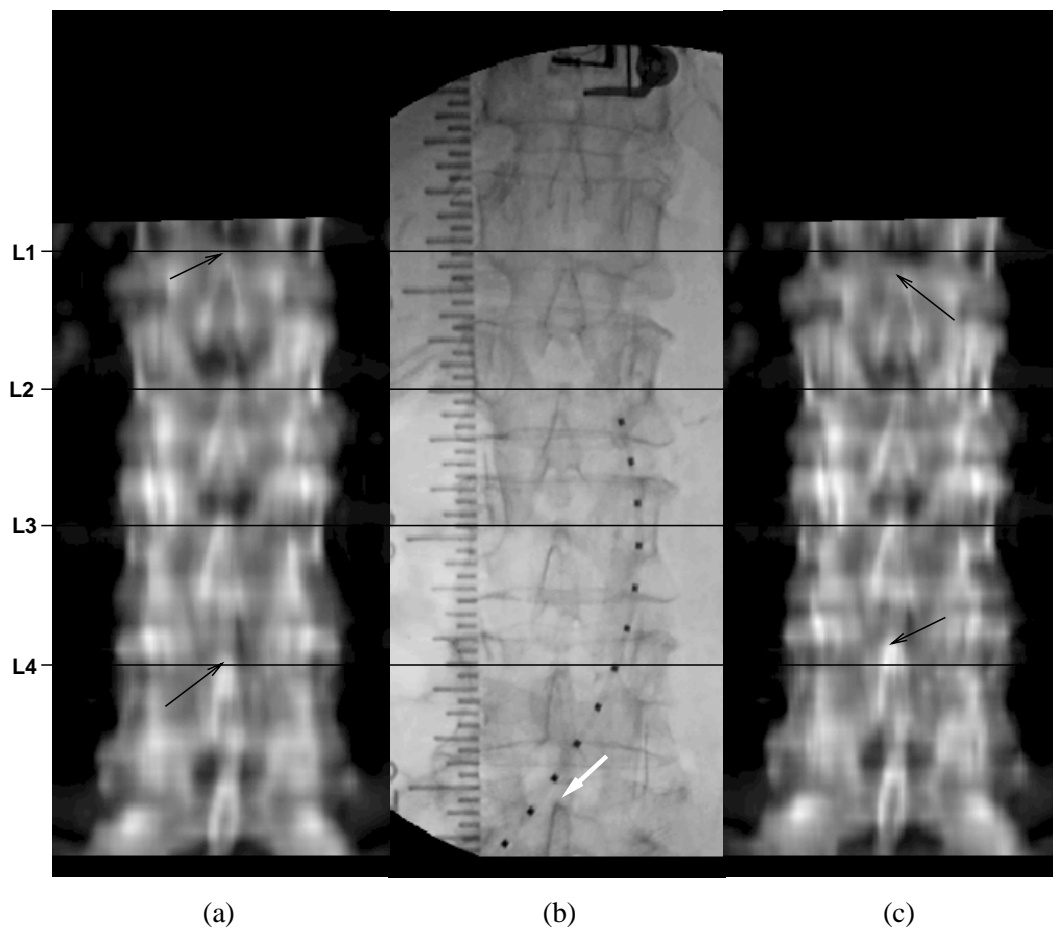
DRR produced with warped CT volume (a), intra-operative fluoroscopy image on which warp was based (b) and DRR produced with pre-operative CT volume (c). DRRs were produced using an average set of extrinsic parameters from registrations to the L1, L2, L3 and L4 vertebrae. The black lines represent the vertical position of the superior surface of the spinous processes in the fluoroscopy image.
